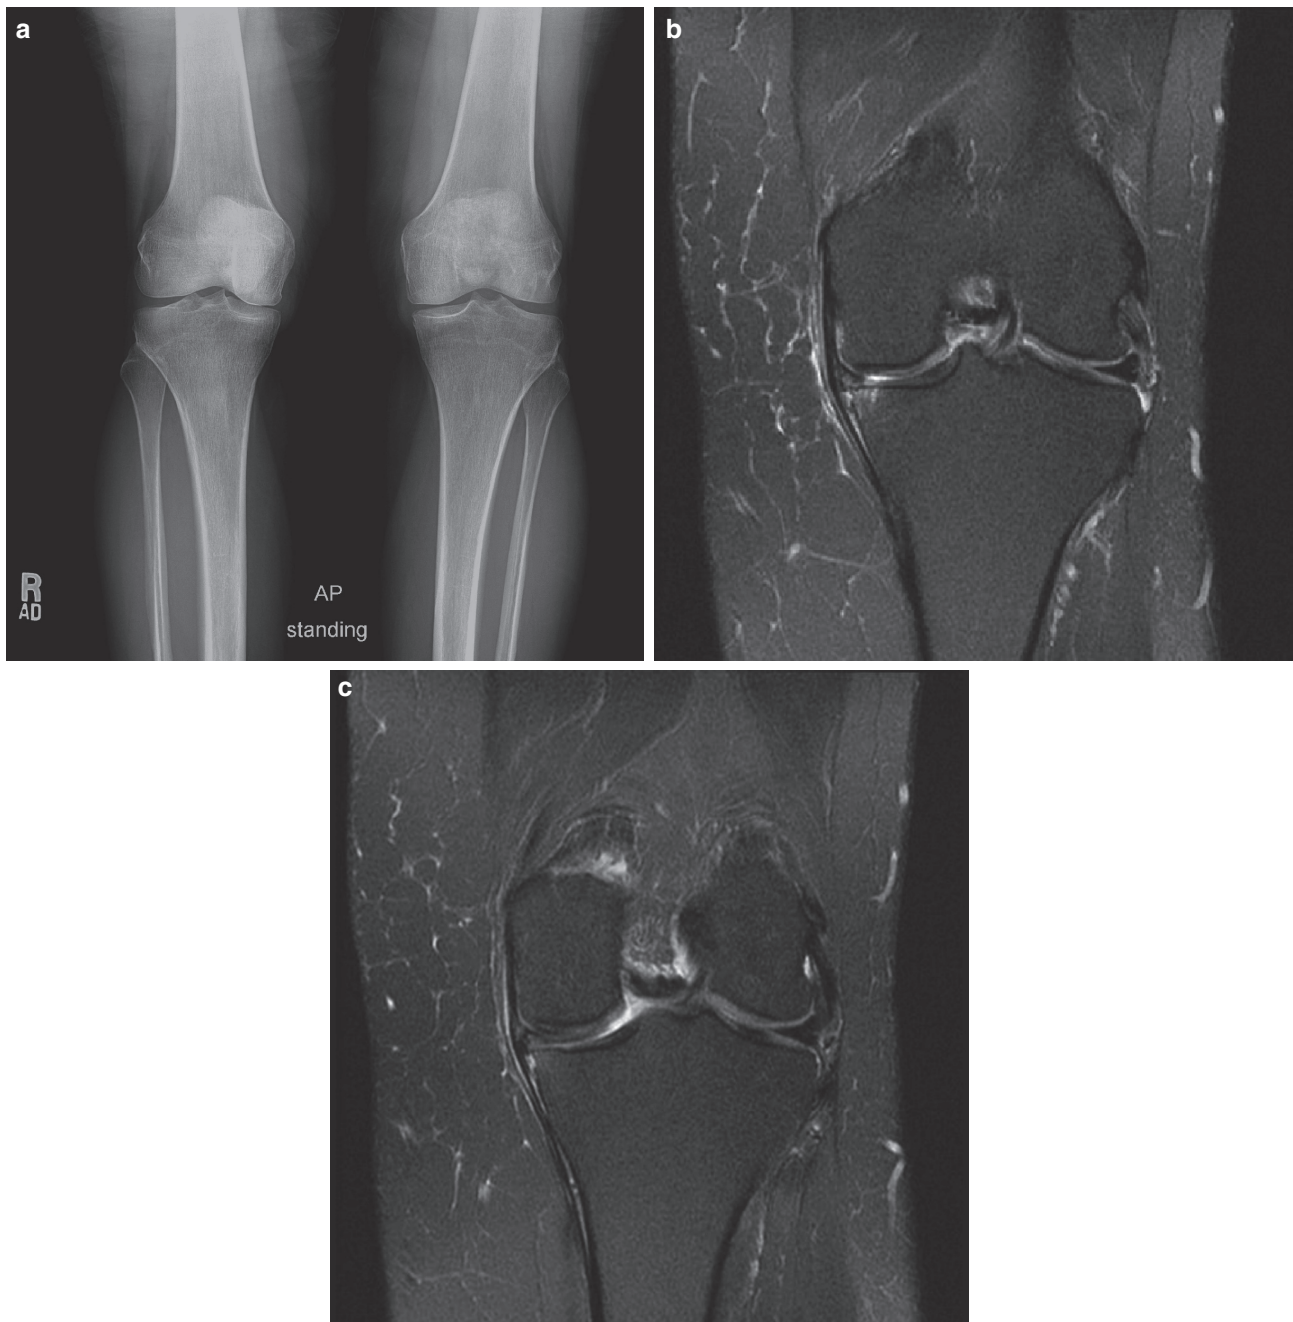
Case 1. (A) Anteroposterior radiographs of the knees demonstrate mild medial compartment narrowing of both knees, with minimal degenerative changes. (B, C) MRI scans shows horizontal cleavage tear of the medial meniscus associated with articular cartilage degeneration and reactive bone edema. (D) Initial arthroscopic view of the medial compartment shows Outerbridge grade III fibrillation of articular cartilage of the femur and tibia. Torn meniscus is initially not apparent. (E) Probing of articular side of the medial meniscus reveals subluxated flap of torn meniscus. (F, G) Resection of unstable flaps of the medial meniscus back to stable rim reveals Outerbridge grade IV changes on the tibial plateau
